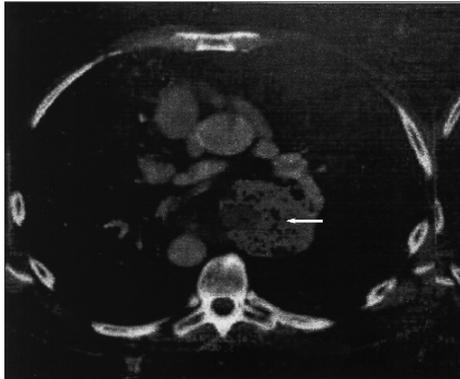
Magnetic resonance imaging, showing the esophageal Gastrointestinal stromal tumors (arrow).
